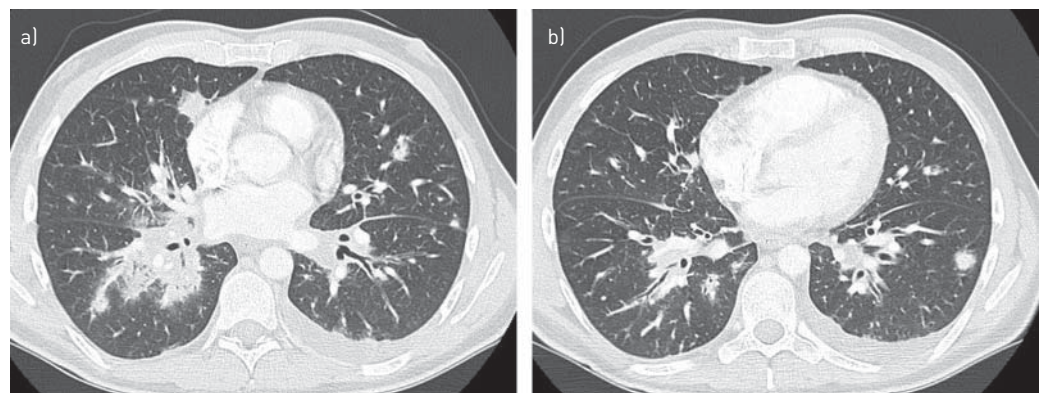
Computed tomography images showing one centrilobular ill-defined nodule surrounded by ground-glass opacities (a), peribronchovascular thickening fusing from the pulmonary hilum and a small left pleural effusion (b), all typical of Kaposi sarcoma.
